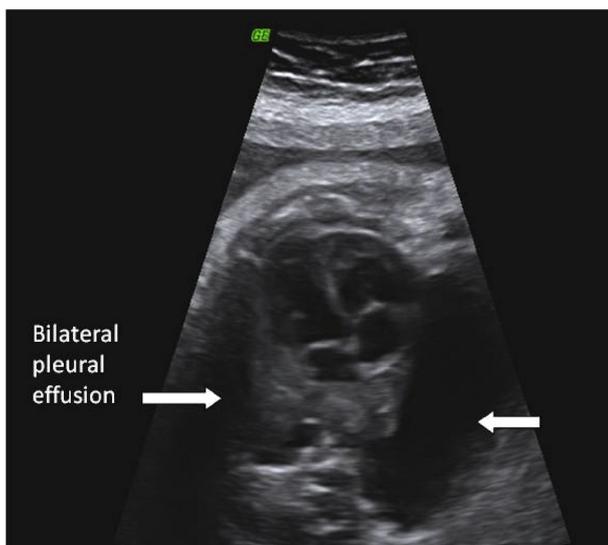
Prenatal ultrasound of Case 1 at 34 weeks of gestation shows bilateral pleural effusions.
